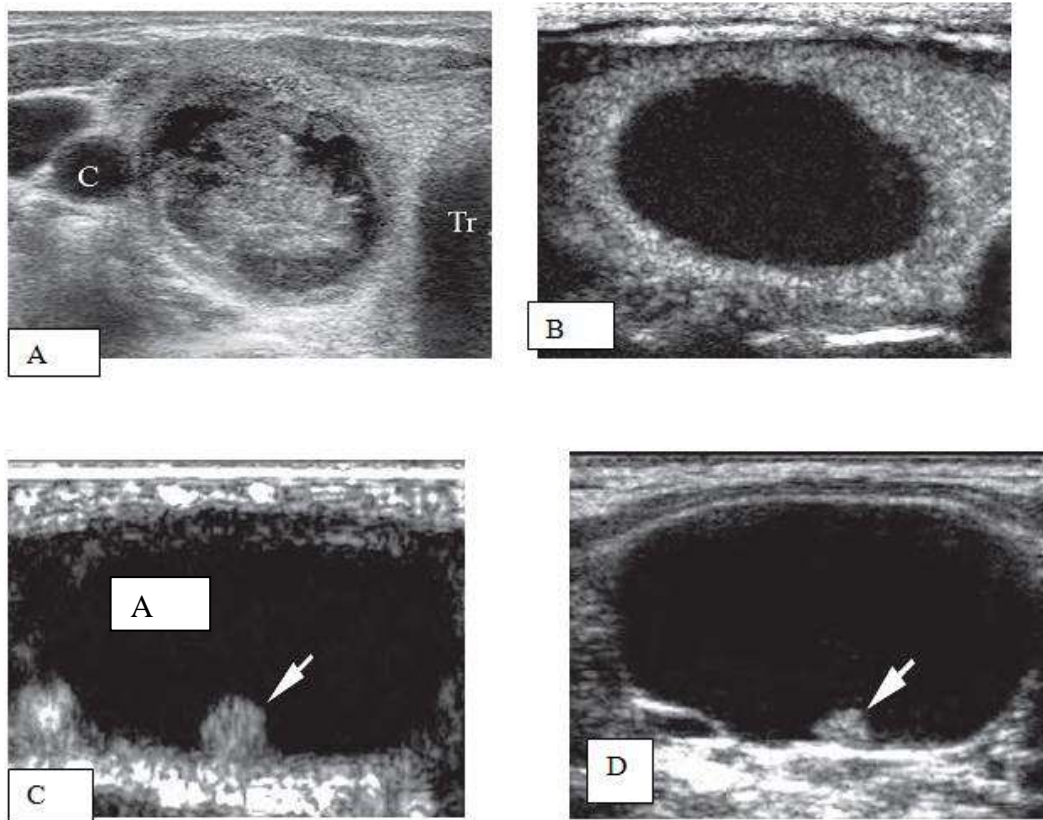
Contrast-enhanced sonography to differentiate benign from malignant fluid-filled thyroid.
